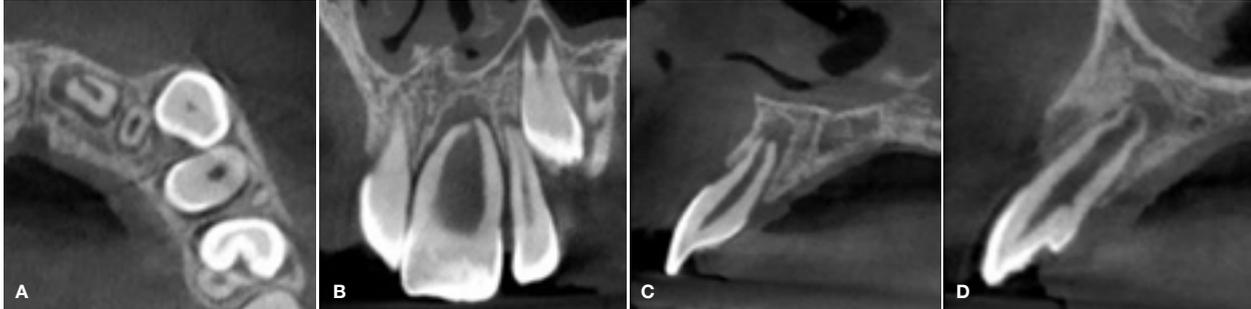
Limited field-of-view CBCT showing: (A) the axial view of the maxillary central incisors demonstrating a periapical lesion around the root tip of the left maxillary central incisor; (B) the coronal view confirming the periapical pathology and incomplete root formation; (C) the sagittal view confirming immature root development with an open apex; and (D) the sagittal view of the vital left lateral incisor presenting with dens invaginatus Type II.
